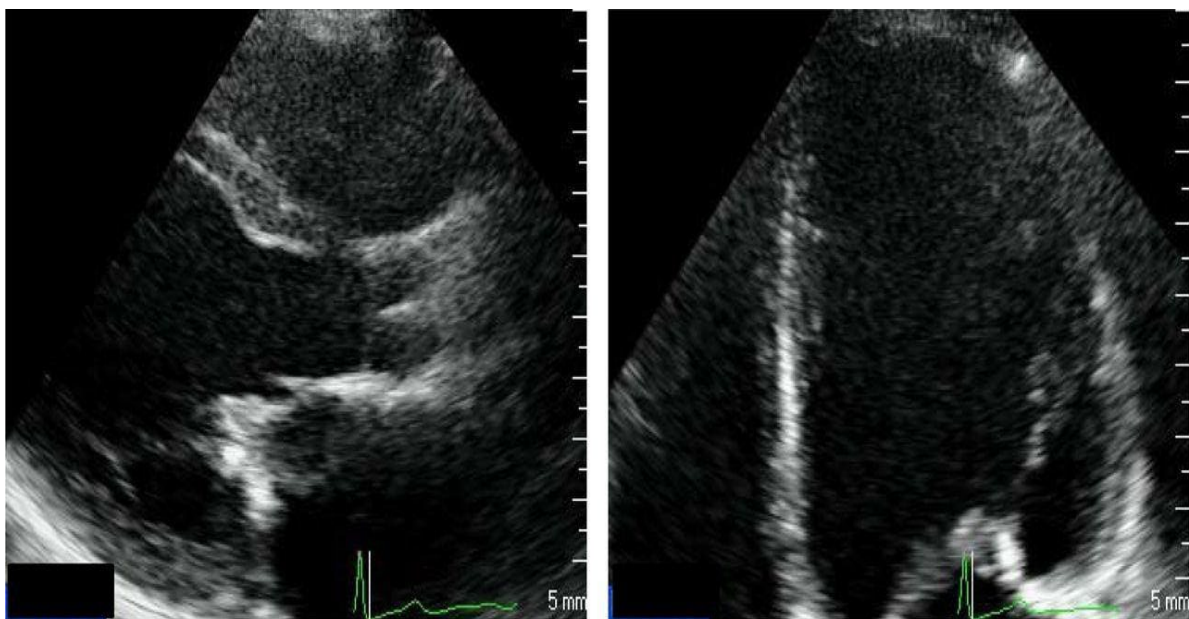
A parasternal long-axis view (left) and an apical four-chamber view (right) of a 28-year-old female showing eccentric left ventricular hypertrophy Source: Marwick *et al.* (2015)
